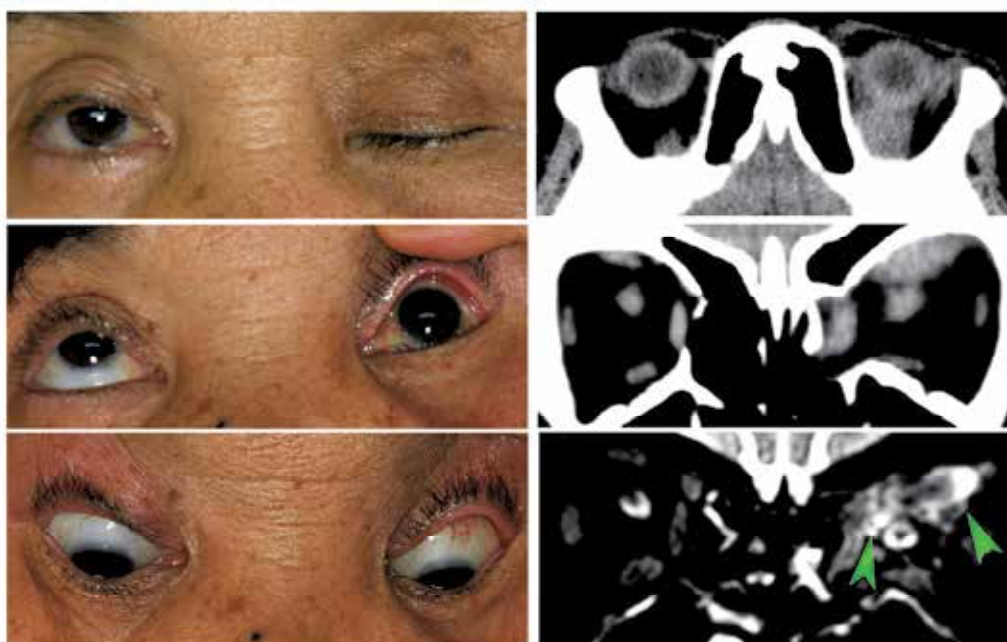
Acute type of atypical idiopathic orbital myositis. Left: External photographs of a 65-year-old woman showing the left blepharoptosis, and also with ocular motility restrictions in the field of action of the affected extraocular muscles. Signs including subacute onset and non-inflammatory conditions indicate that this is atypical idiopathic orbital myositis. Right: CT images shows indistinct swelling around the superior rectus muscle of the left eye. Fat-suppressed T2-weighted MR image shows hyperintense signal around the fascicular structures (arrowhead). Following steroid pulse therapy, she completely recovered from the signs and symptoms.
